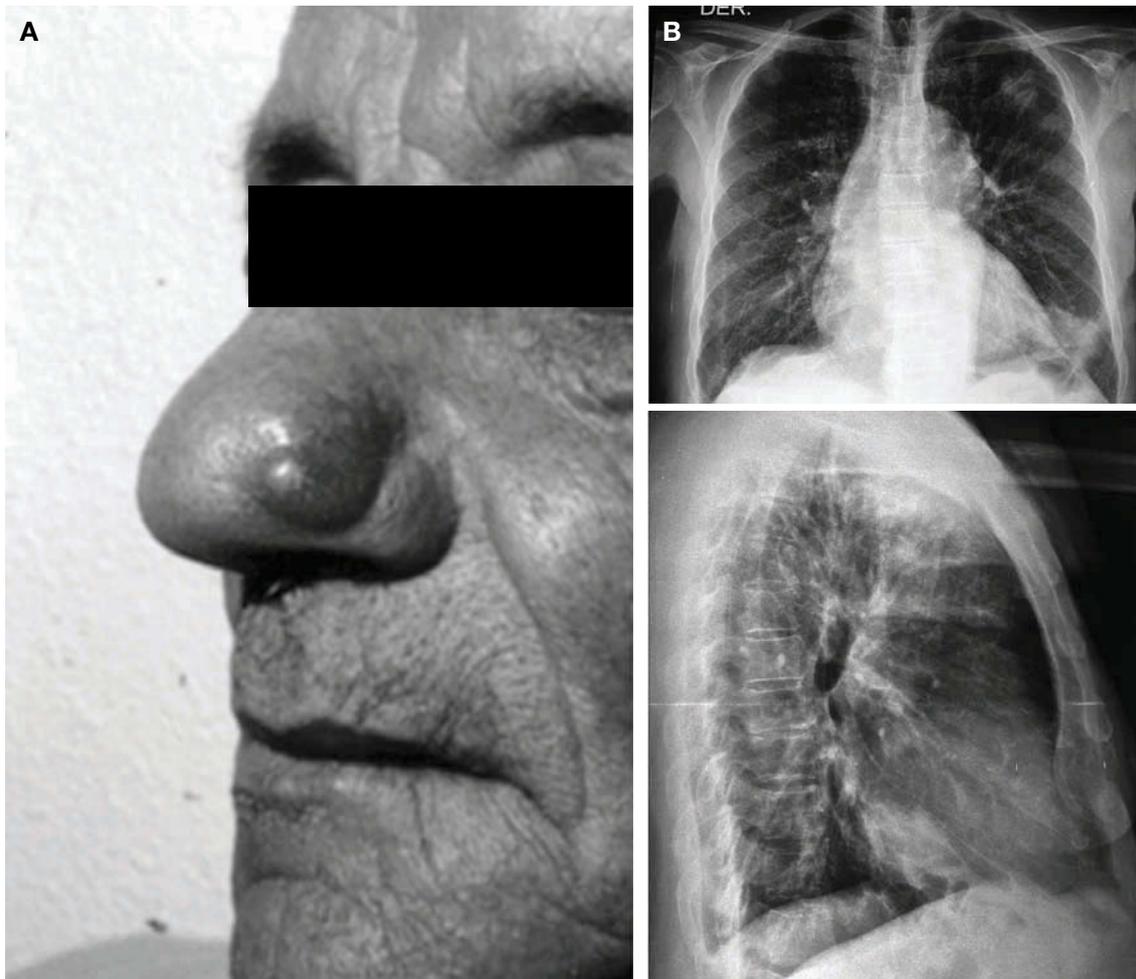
Raised metastatic lesion on the left wing of the nose (A) and posteroanterior and lateral chest radiograph (B), showing an irregular lesion in the left upper lobe, indicating bronchogenic carcinoma.
